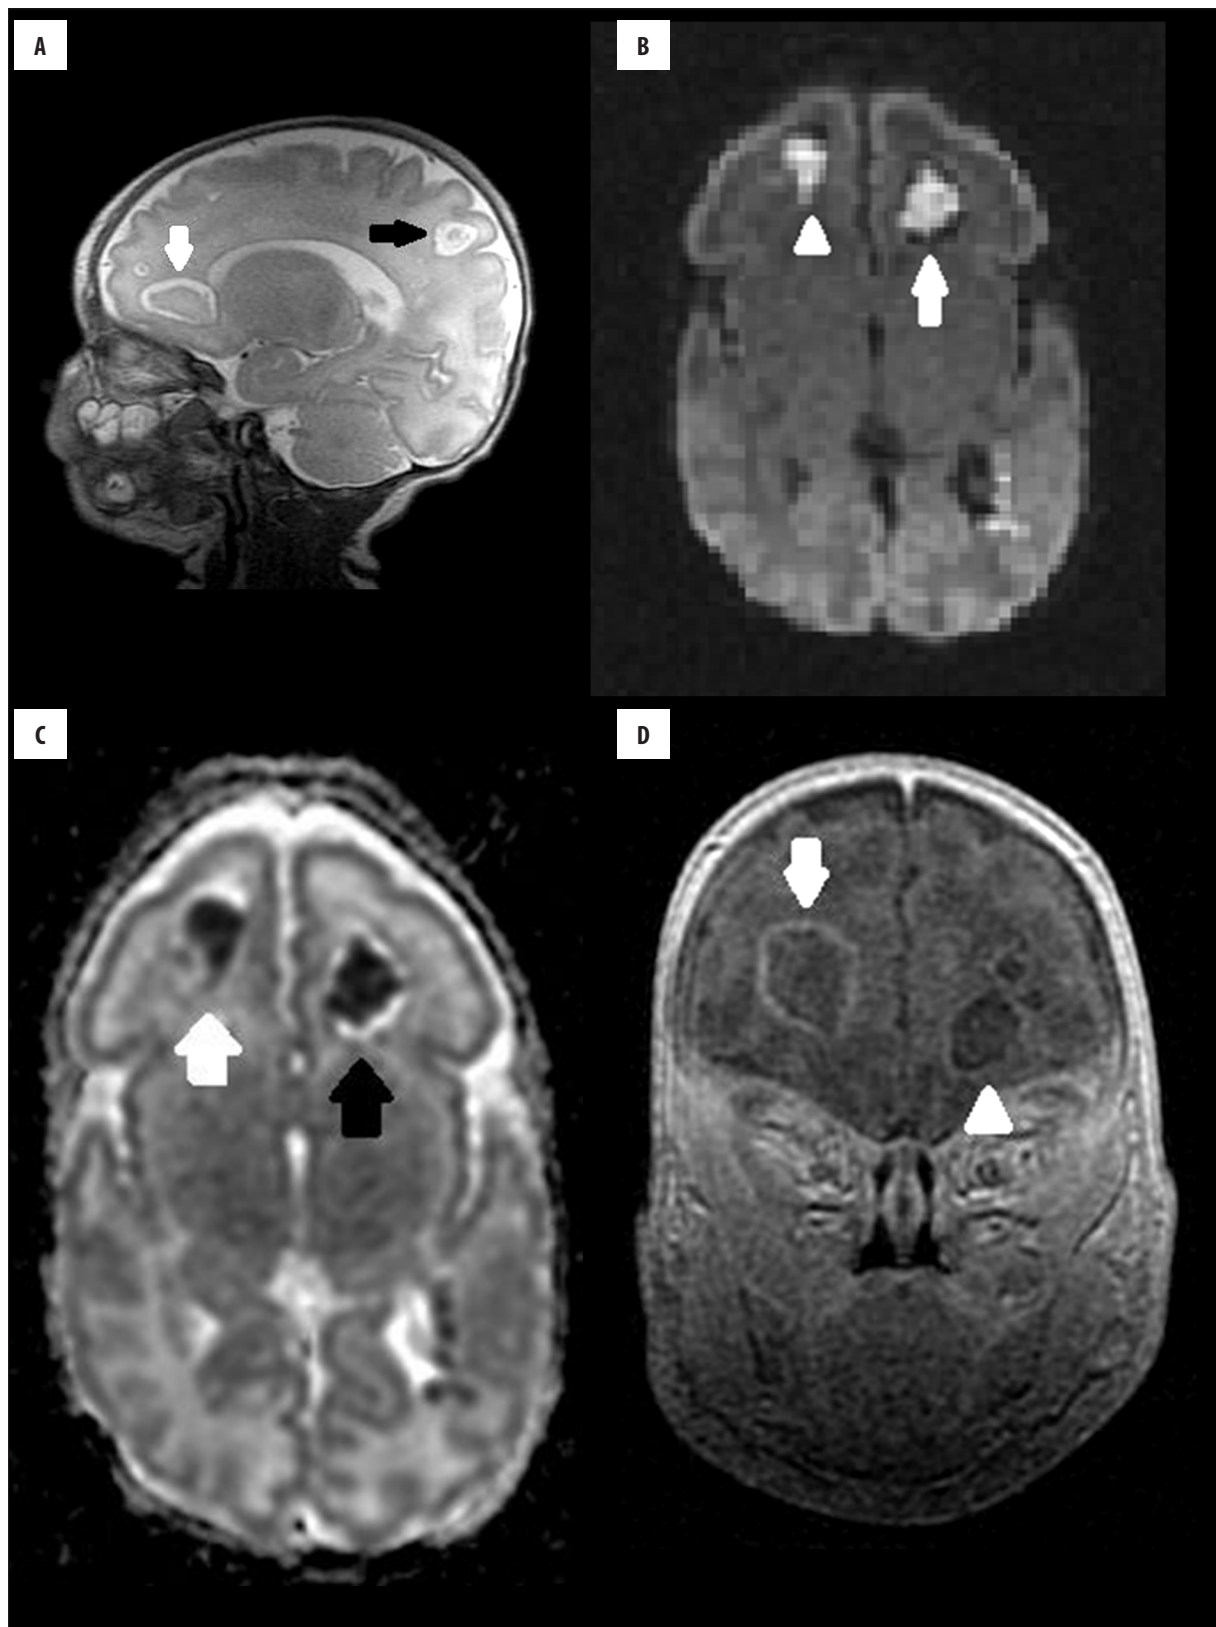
Brain MRI of the patient on the 44th day of life. Multiple abscesses. (A) T2-weighted image in the sagittal plane: two abscesses are located in the frontal lobes (white arrow) and one in the parietal lobe (black arrow). (B) DWI sequence in the axial plane: typical, hyperintense contents of the abscesses in both frontal lobes (right side-white arrow, left side-arrowhead). (C) ADC map corresponding to Figure (B) with very low values of ADC (black and white arrow), typical of an abscesses. (D) T1-weighted, post-contrast image in the coronal plane. Contrast enhancement of the abscess capsule is readily observed in the right frontal lobe (white arrow).
